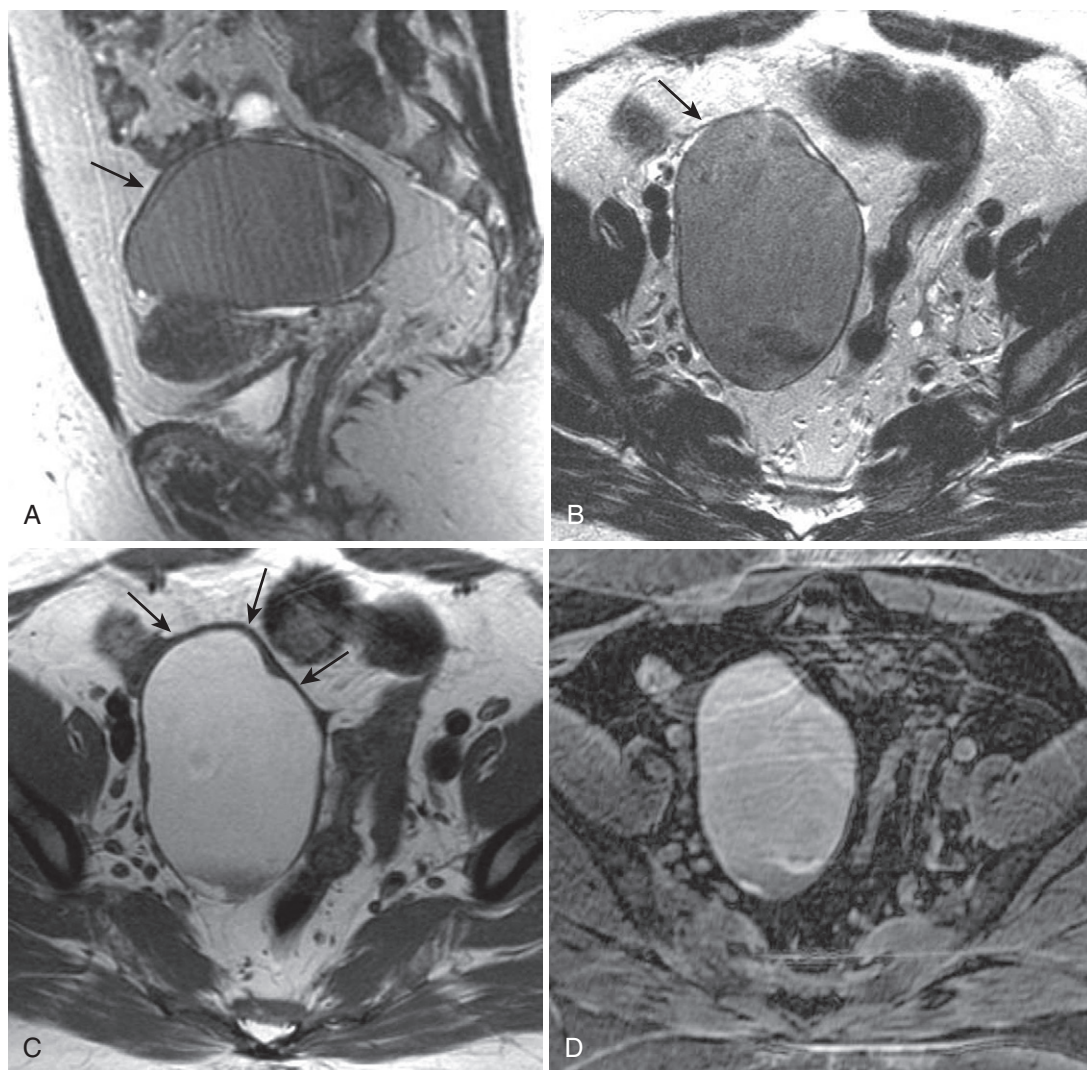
Endometrioma. Sagittal scout (A) and axial (B) T2-weighted images display a large moderately hypointense right adnexal lesion (*arrow*) dwarfing the adjacent uterus. C, The corresponding T1-weighted image confers hyperintensity and discloses mild wall thickening (*arrows*), an occasional feature seen in endometriomas. D, Preservation of hyperintensity on the T1-weighted fat-saturated image excludes the possibility of lipid and confirms the presence of blood.
